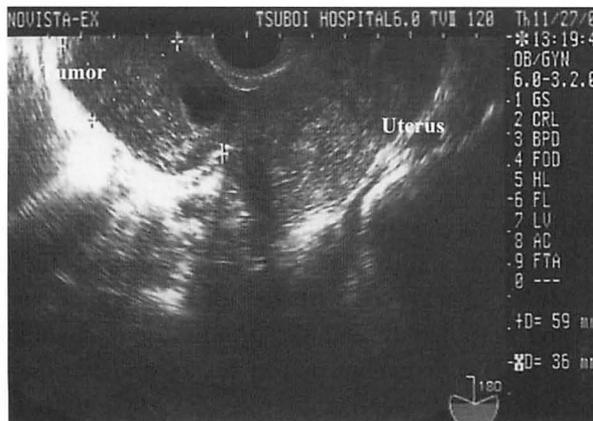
Ultrasoundgraphy of case 2 revealed 6×3.5 cm-sized tumor, neighboring the uterus.
